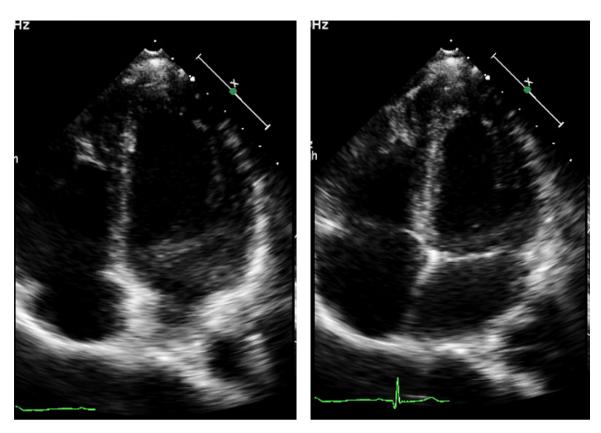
Transthoracic echocardiogram. (Left) Four-chamber view in end-diastole. (Right) Four-chamber view in end-systole showing apical cap hypokinesis.
